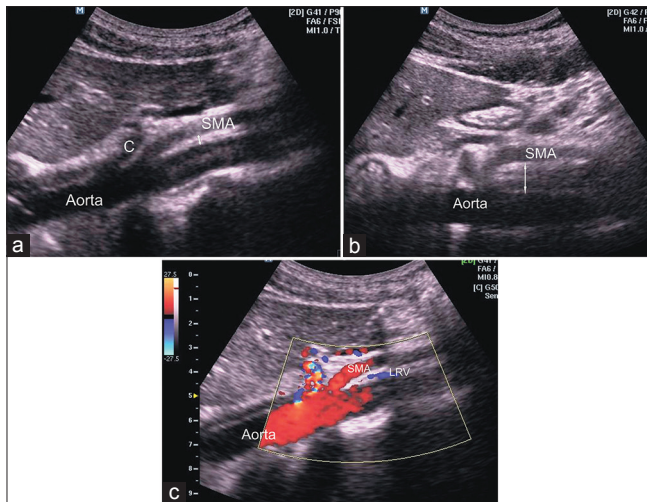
(a) Longitudinal ultrasound images showing the aorta, coeliac, and mesenteric arteries. The acute aortomesenteric angle and thin tissue layer between the superior mesenteric artery and aorta are appreciated; (b) Comparison with the almost right angle aortomesenteric angle projection and thicker tissue layer in another 26-year-old male patient; (c) Doppler image showing the left renal vein (blue) located between the superior mesenteric artery and aorta
